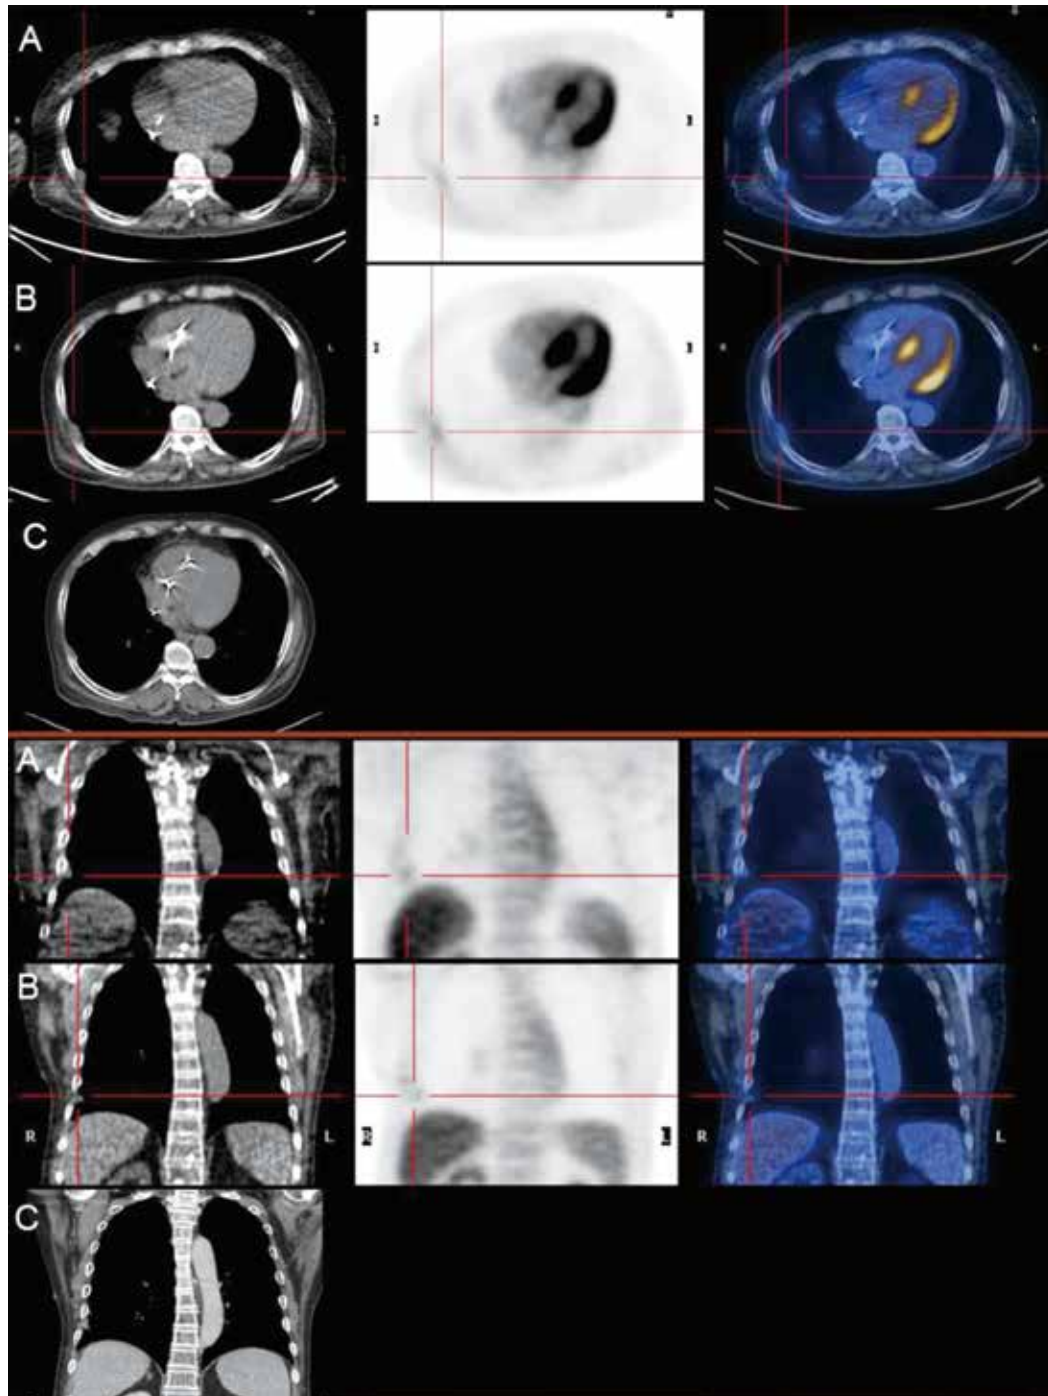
Case 2: Axial (upper) and coronal (lower) positron emission tomography/computed tomography (PET/CT) images and diagnostic chest CT image. PET/CT images obtained with the arms positioned downward and during tidal breathing (A) show a mass (red crosshair); corresponding delayed images obtained with the arms positioned upward and during tidal breathing (B) shows that the lesion decreased in size and retreated into the seventh intercostal space. The mass decreased in size and retreated into the space on the delayed PET/CT images. However, mild FDG uptake is observed on the initial PET/CT images, and no significant increase in FDG uptake is noted on the delayed PET/CT images. Prior chest diagnostic chest CT (C) image shows less prominence at this site.
